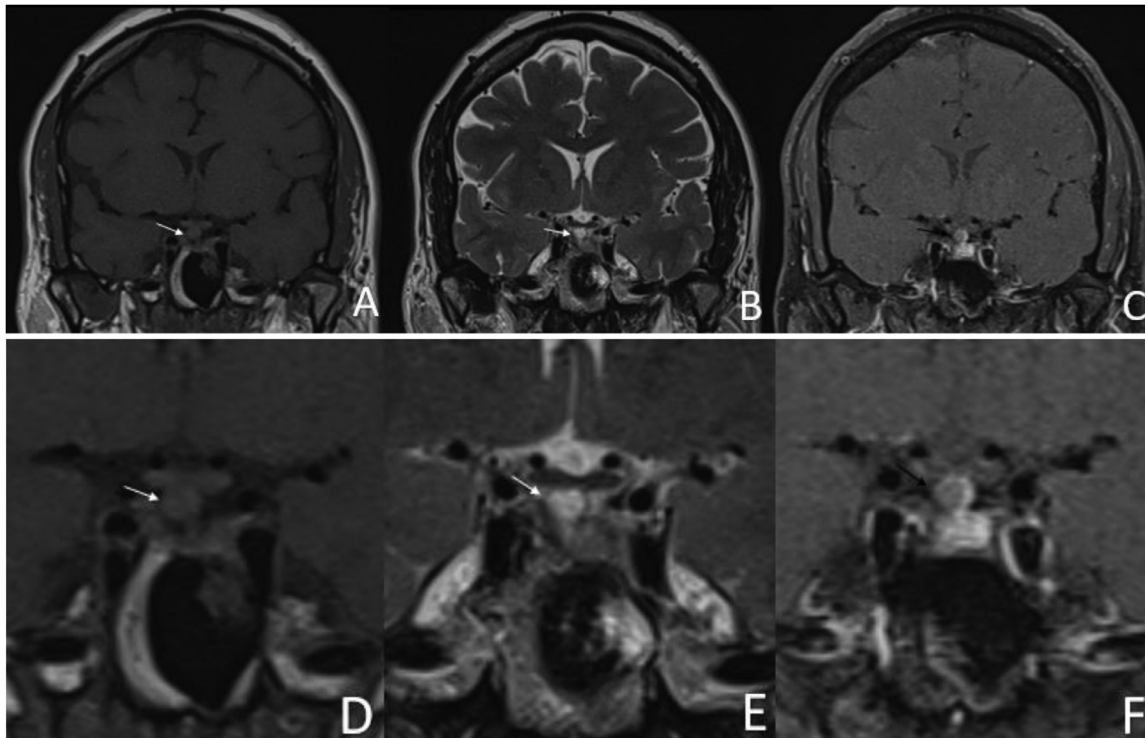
MRI images with coronal view: a suprasellar round shape formation, appearing iso intense compared to the brain on the T1-weighted images (A,D) and hyperintense on the T2 weighted images (B,E) (white arrow). T1 weighted images following contrast injection show peripheral enhancement (C,F) (black arrow). The tumor presents a contact with pituitary stalk medially and the optic chiasm above.
